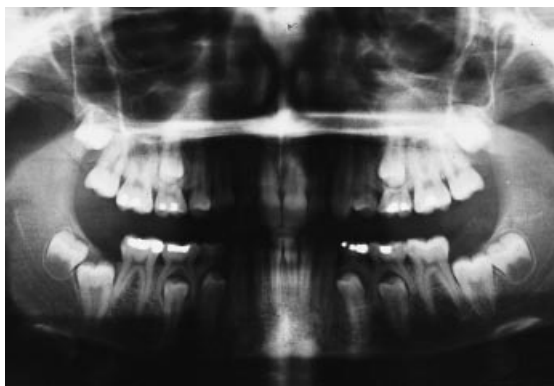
Orthopantomogram of a girl aged 15 years with arrested eruption of lower second molars. Taurodontic root forms are seen on all second molars.
